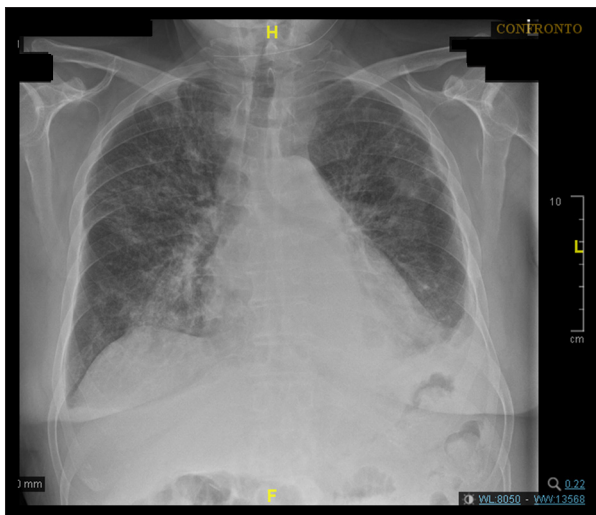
Lung involvement of the disease. Chest x-ray showing several bilateral parenchymal foci with ill-defined margins, localized mainly in the perihilar regions. Presence of left costophrenic angle blunting.
